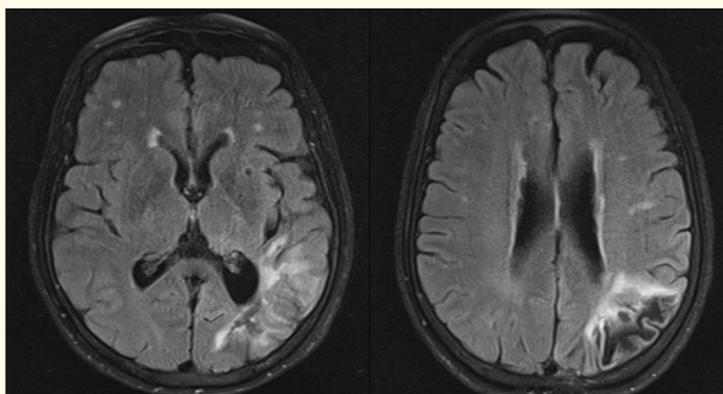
Brain MRI at ER. FLAIR images show an old infarction at the left parietal area.
